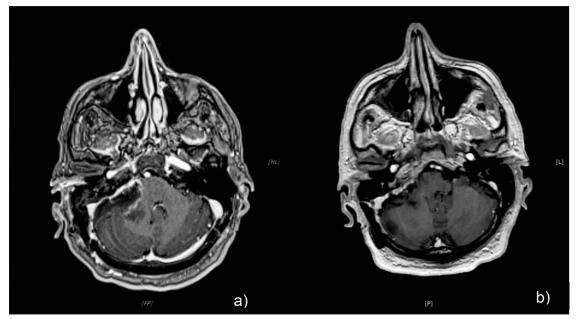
(A) The follow-up brain MRI utilizing T1 MPRAGE sequence immediately post-operation showing no signs of any bleeding or complications. (b) The follow-up brain MRI at 3 months postoperatively, employing the T1 MPRAGE sequence demonstrates the absence of tumor recurrence.
